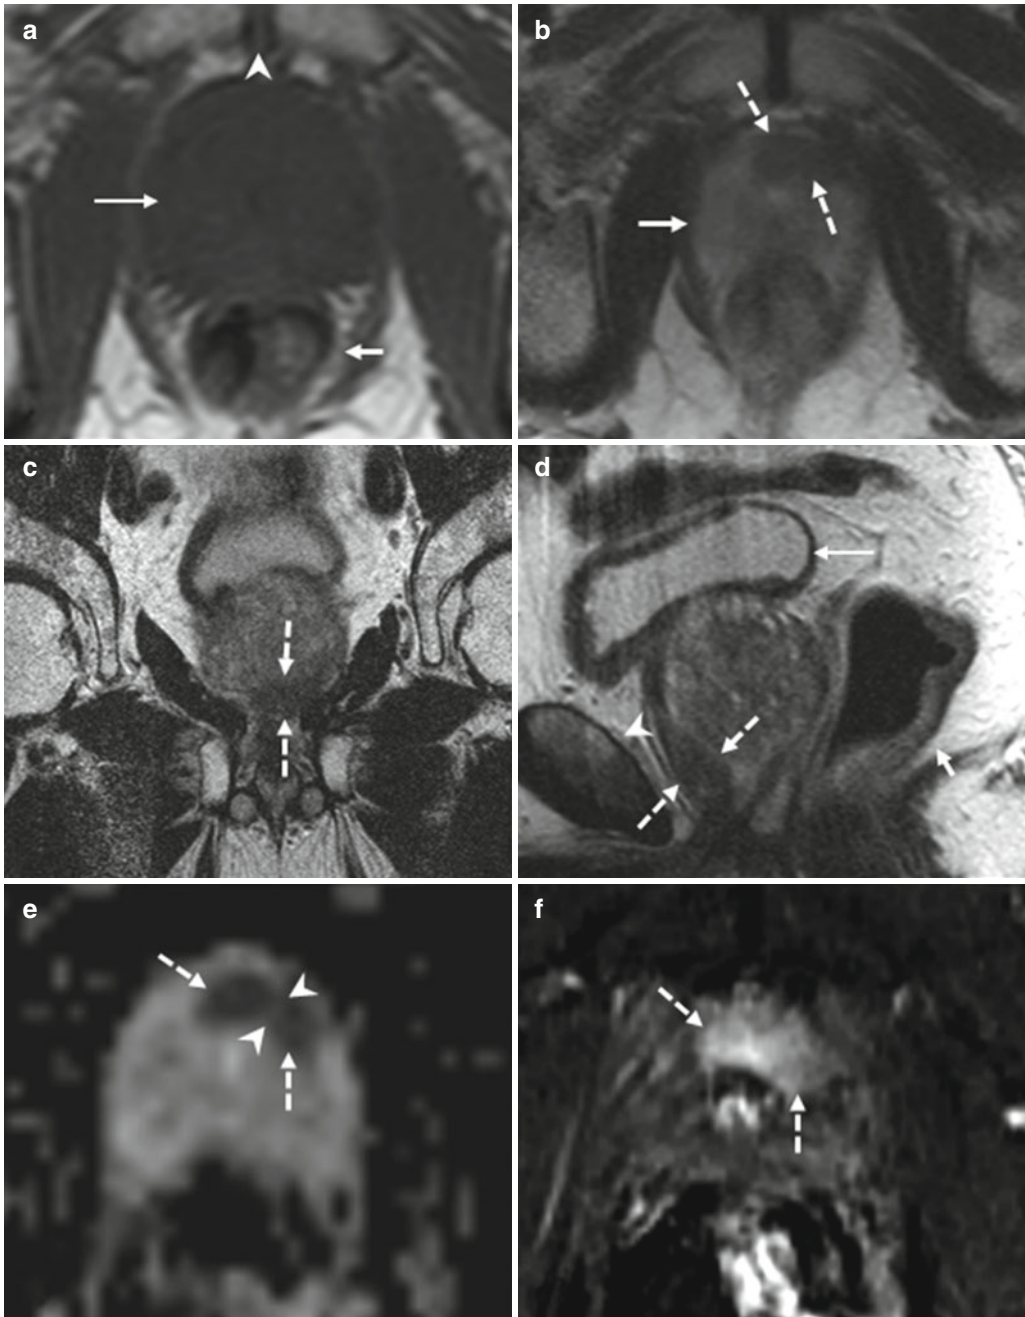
(a–f) 74 years old, underwent randomized prostate biopsy both 2 years ago and 3 months ago because of increasing PSA (last value 15.6 ng/ml). Axial T1-weighted (TR: 550; TE: 9.3) sequence (a) shows a prostate (long arrow), homogeneously and regularly hypointense, with increased volume (estimated 89 ml). In this plane the rectum (short arrow) and symphysis pubis (arrowhead) can be recognized. On axial T2-weighted (TR: 3600; TE: 116) sequence (b), acquired just below a, the prostate (continued arrow) appears homogeneously hyperintense with the exception of an hypointense nodule, 10 mm long, at level of the anterior apex, mostly included in the left lobe (dashed arrows); on
